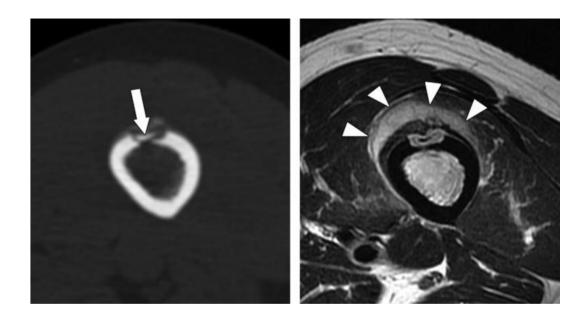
Intracortical abscess of the femoral shaft. CT showing a lytic lesion with an irregular margins and eccentric sequestrum (arrow). Axial T2WI MR image showing hyperintense lesion with adjacent periosteal reaction(arrow heads) (4).
